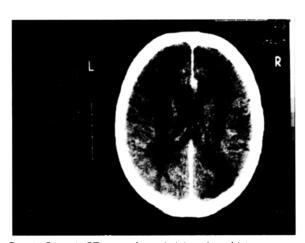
Case 1. CT scan after administration of intravenous contrast medium showing a right parieto-occipital hypodense lesion consistent with encephalomalasia.
